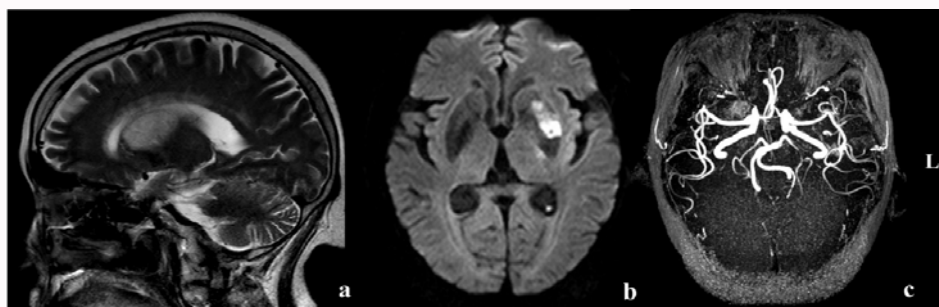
a) Sagittal cranial MRI shows long T2 signal in the lenticular nucleus of the left basal ganglia; b) DWI shows restricted diffusion of the left globus pallidus; c) MRA shows no significant stenosis in the left internal carotid artery system.
